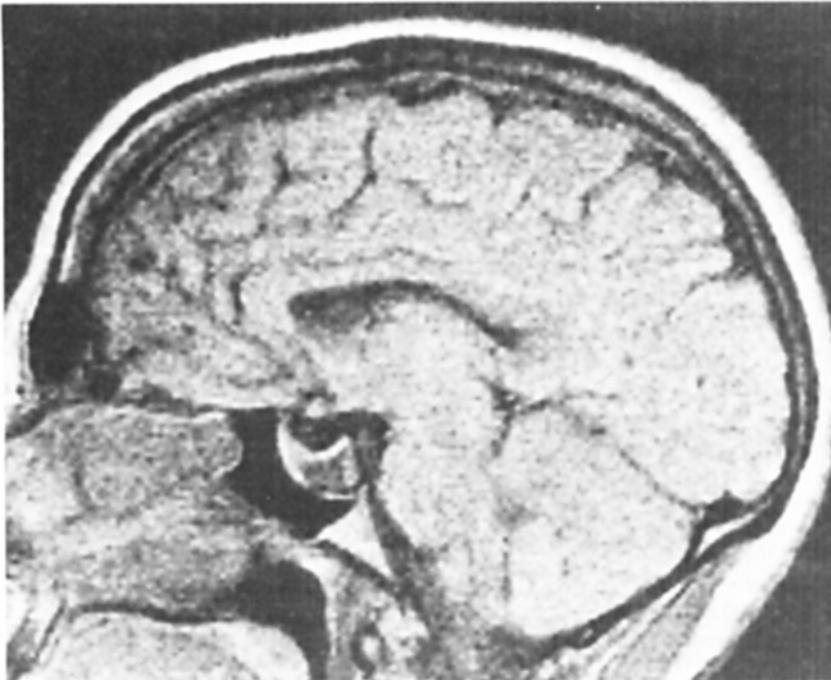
At 10 months follow-up MRI showed the same tumour size as in Fig. 2.
